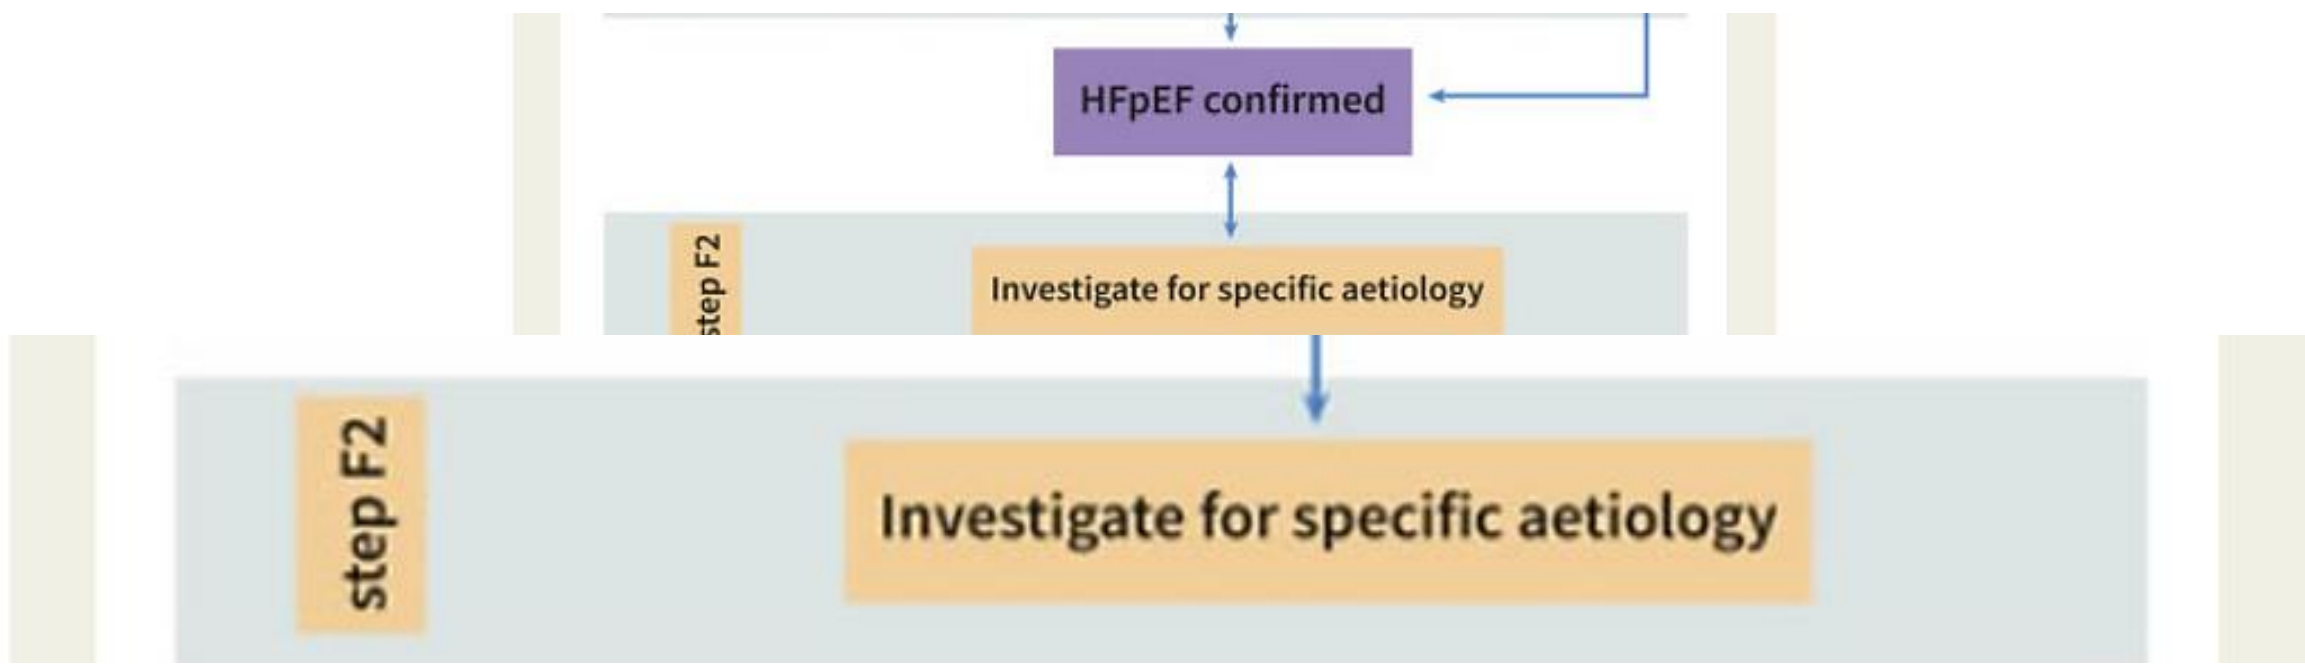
Step 3 (F): Functional tests in cases of diagnostic uncertainty. (A, upper panel) It shows the diastolic stress test workup with exercise echocardiography is shown. If key haemodynamic abnormalities are identified, a definite heart failure with preserved ejection fraction diagnosis can be made. (B, lower panel) It shows the invasive haemodynamic measurements at rest (left) or during exercise (right) that may complement stress echocardiography and are recommended in cases with remaining diagnostic uncertainty.
